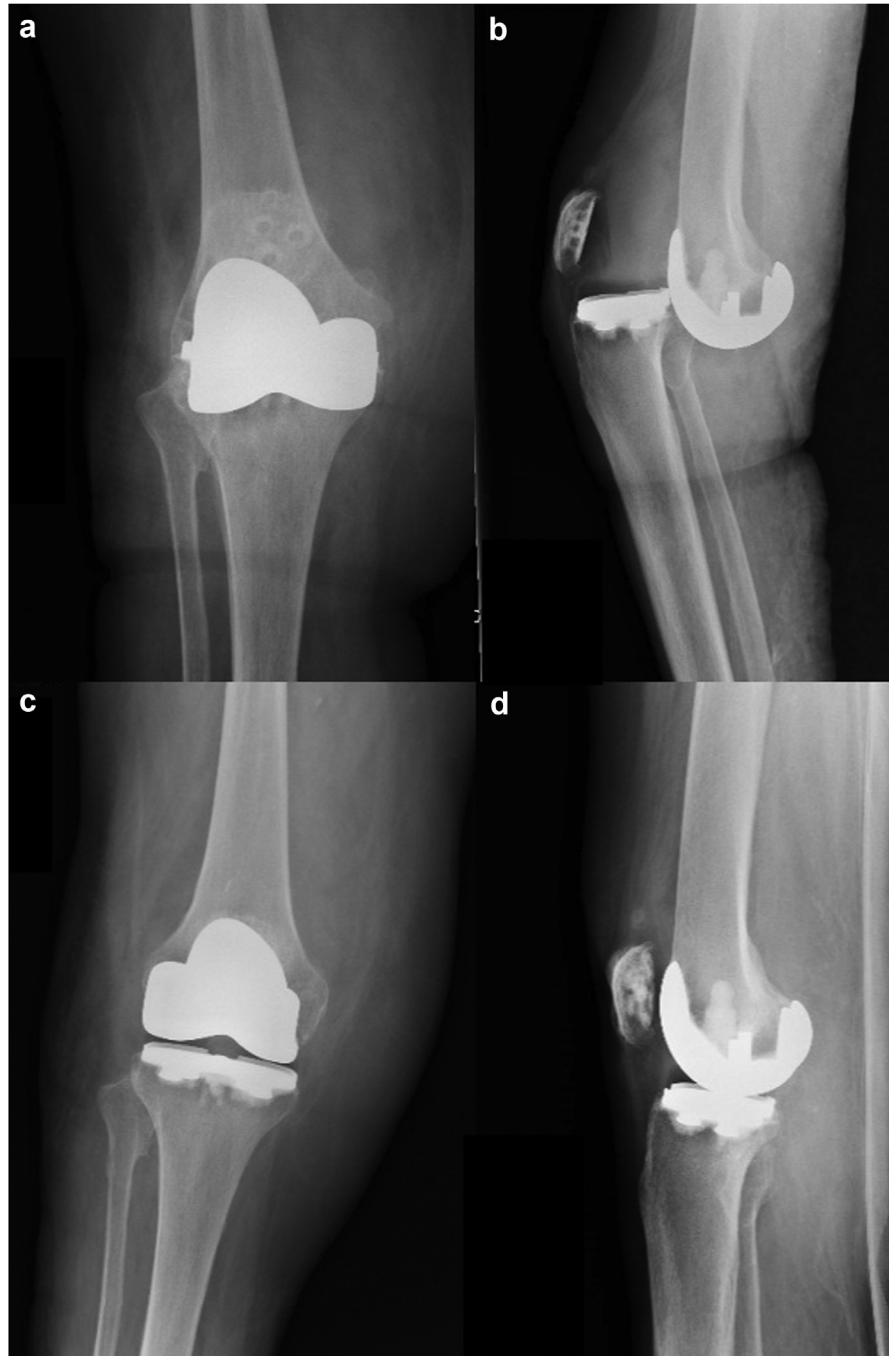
AP and lateral right knee radiographs demonstrating prosthetic anterior knee dislocation, before (a, b) and after (c, d) reduction. Image “d” demonstrates an intra-articular effusion with residual anterior subluxation, with likely underlying cruciate ligament injury with persistent instability.
